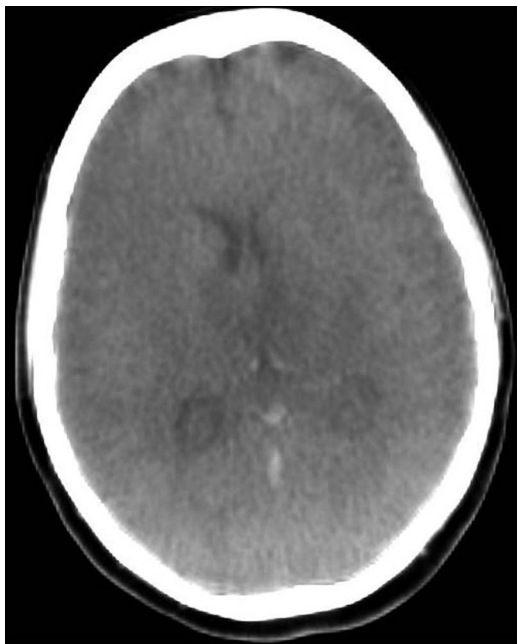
Axial scanogram acquired on a biplane neurovascular X-ray system (Philips Allura XperCT) showing bithalamic low attenuation and cord sign (image degraded by artefact).
